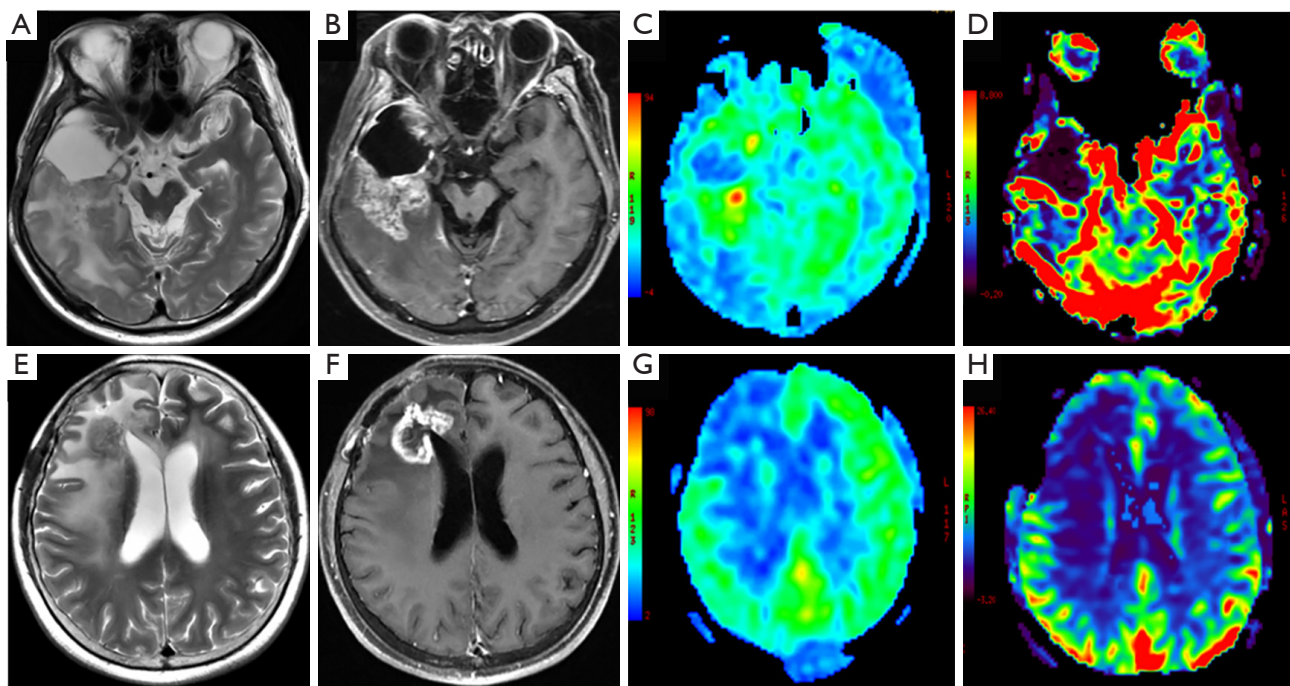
MRI findings of glioma recurrence and PsP. (A-D) Recurrent IDH-wildtype glioblastoma in the right temporal lobe in a 54-year-old man. (A) Axial T₂-weighted imaging shows ill-defined lesion with heterogeneous hyperintensity. (B) Axial post-contrast T₁-weighted imaging shows heterogeneous enhancement. (C) ASL image shows iso-perfusion mixed with spot-like hyper-perfusion. (D) The CBV map of DSC-MRI shows hyper-perfusion in most of the lesion. (E-H) PsP in IDH-mutant astrocytoma after surgery and radiotherapy in the right frontal lobe in a 53-year-old woman. (E) Axial T₂-weighted imaging shows well-defined lesion with iso-intensity. (F) Axial post-contrast T₁-weighted imaging shows ring enhancement. (G) ASL image shows hypo-perfusion. (H) The CBV map of DSC also shows hypo-perfusion. MRI, magnetic resonance imaging; PsP, pseudoprogression; ASL, arterial spin labeling; CBV, cerebral blood volume; DSC-MRI, dynamic susceptibility contrast magnetic resonance imaging.
